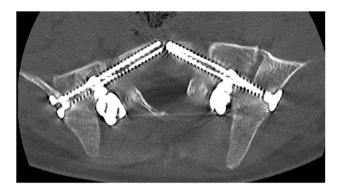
Transverse plane on CT-scan. The direction of the screw is oblique from outside to inside, and from back to front, passing in front of the spinal canal to reach the body of S1
